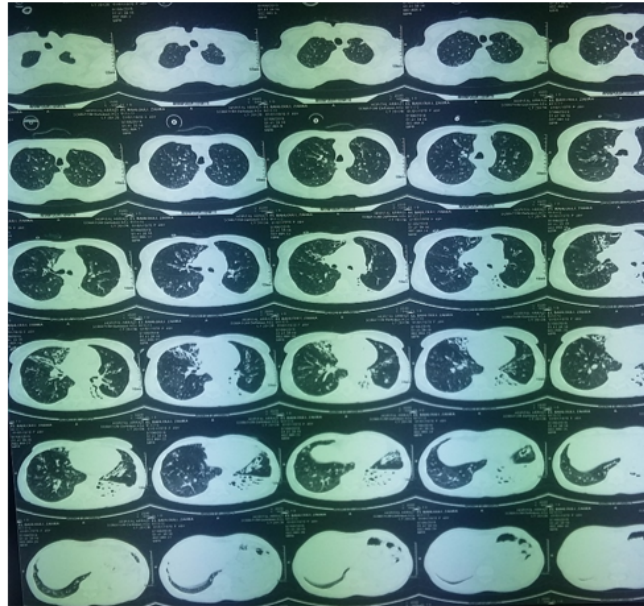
Initial thoracic CT angiography (axial window), foci of multiple bilateral diffuse cystic and moniliform bronchiectasis, predominantly cystic, predominant in the right upper lobe and left lower lobe with signs of bronchial superinfection, focus of systematized lower lobar parenchymal condensation left.
